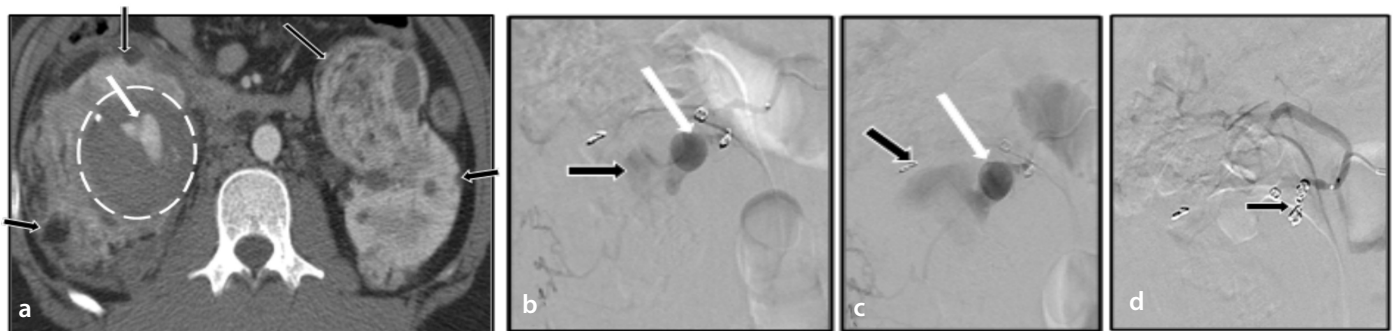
An axial contrast-enhanced CT (a) through the kidneys demonstrates numerous bilateral angiomyolipomas (black arrows). A hematoma is present in the right medial midpole (white circle), with central pseudoaneurysms (white arrow). (b, c) Digital subtraction angiography images of the right kidney demonstrate the pseudoaneurysm (white arrow) with active contrast extravasation (black arrow) into the retroperitoneum, which was subsequently treated with coil embolization (d) (black arrow). CT, computed tomography.
